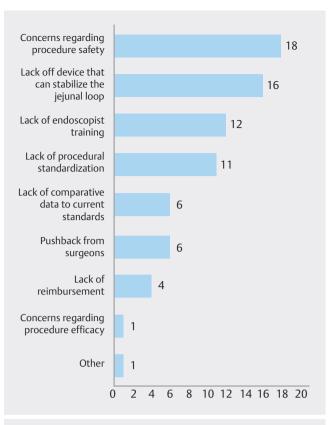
Views of 21 expert endosonographers in the United States about the most significant barriers to widespread to the adoption of EUS-guided gastroenterostomy.
